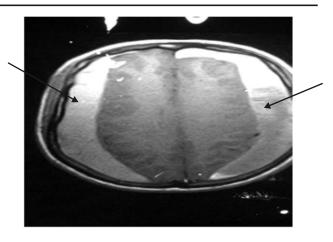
Axial T1 weighted MR image in another patient with MRI more eloquently showing bilateral hyperintense cresentric shaped collection (black arrows) extending from frontal to occipital region-(Bilateral subacute subdural haematomata).
